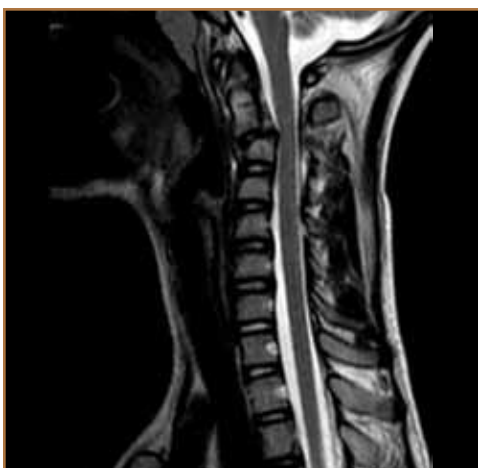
MRI of cervical spine shows severe spinal canal stenosis from the disruption of the C2-C3 intervertebral disc.
